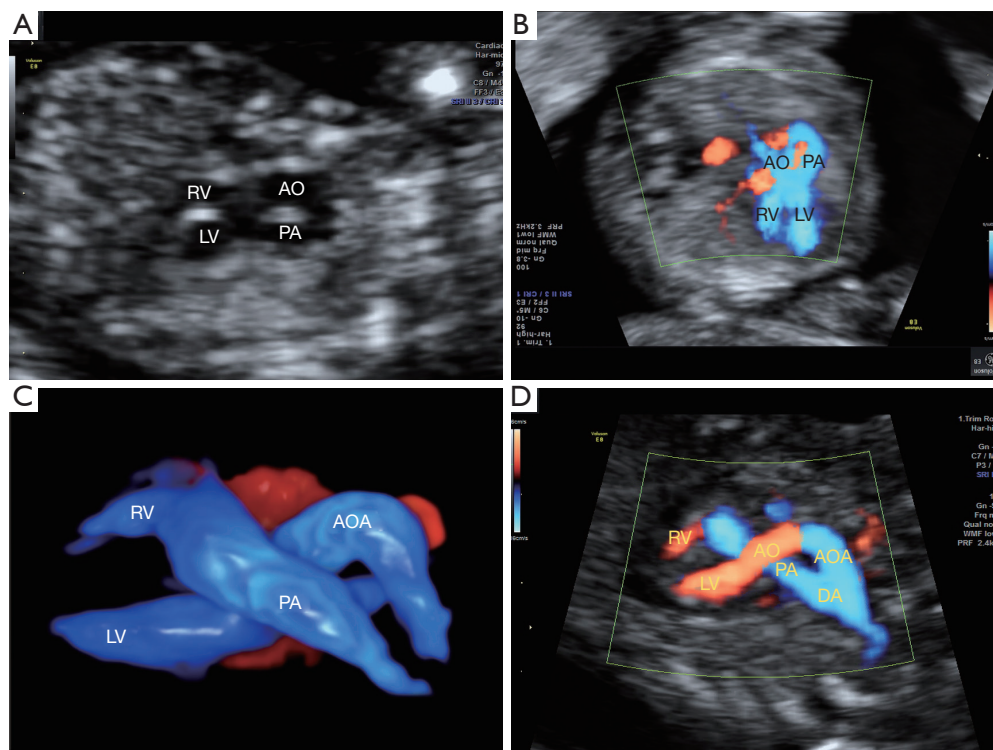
“ ζ ” blood outflow. (A) Doppler “ ζ ” shape blood outflow of figure by transabdominal, 12⁺⁴ weeks; (B) Doppler “ ζ ” shape blood outflow of figure by transvaginal, 12 weeks; (C) Doppler “ ζ ” shape blood outflow of figure by STIC, 22 weeks; (D) Doppler “ ζ ” shape blood outflow of figure by Transvaginal, 14⁺⁵ weeks. STIC, spatial and temporal image correlation; PA, pulmonary artery; RV, right ventricle; LV, left ventricle; AO, aorta; AAO, ascending aorta.
